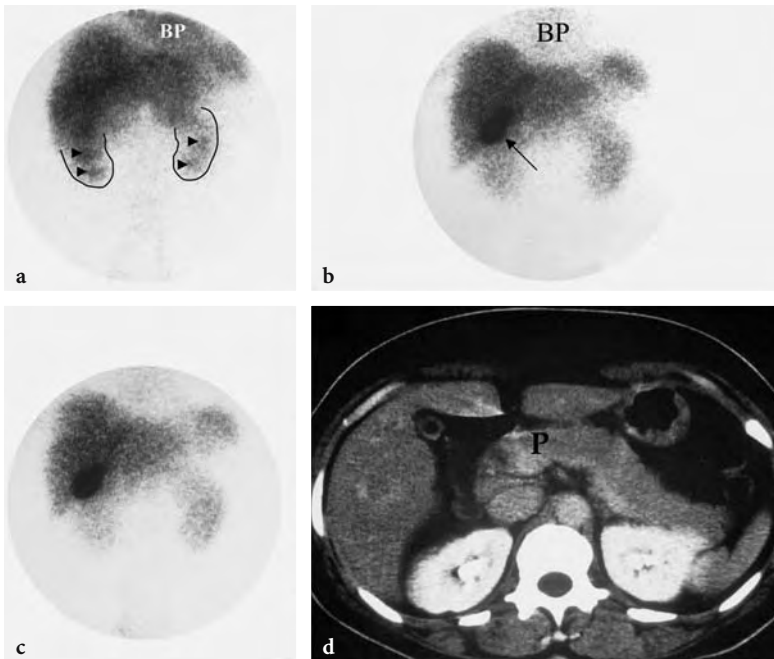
An example of an acute common bile duct obstruction (probably within 24 h of study initiation) by an inflamed pancreas is depicted. a The static view obtained at 5 min after injection shows increased cardiac blood pool (BP) activity in this alcoholic patient with liver cirrhosis. Vicarious renal excretion (the renal shine through from under the liver is outlined in black) is prominent with some focal concentration in the calices (arrowheads). b The image at 50 min revealed an unequivocal gallbladder filling with radioactive bile (arrow), but no activity in the bowel. There is a hint of BP activity, which in conjunction with parenchymal tracer retention points to significant hepatocellular disease and intrahepatic cholestasis. c At 2 h, the patient was given a cholecystikinin challenge. The image at 30 min after the initiation of CCK showed no GB contraction or bowel activity. This pattern persisted on the 24-h image (not shown here). d A CT scan showed an enlarged pancreas (P) that was later confirmed to have caused the common bile duct obstruction
